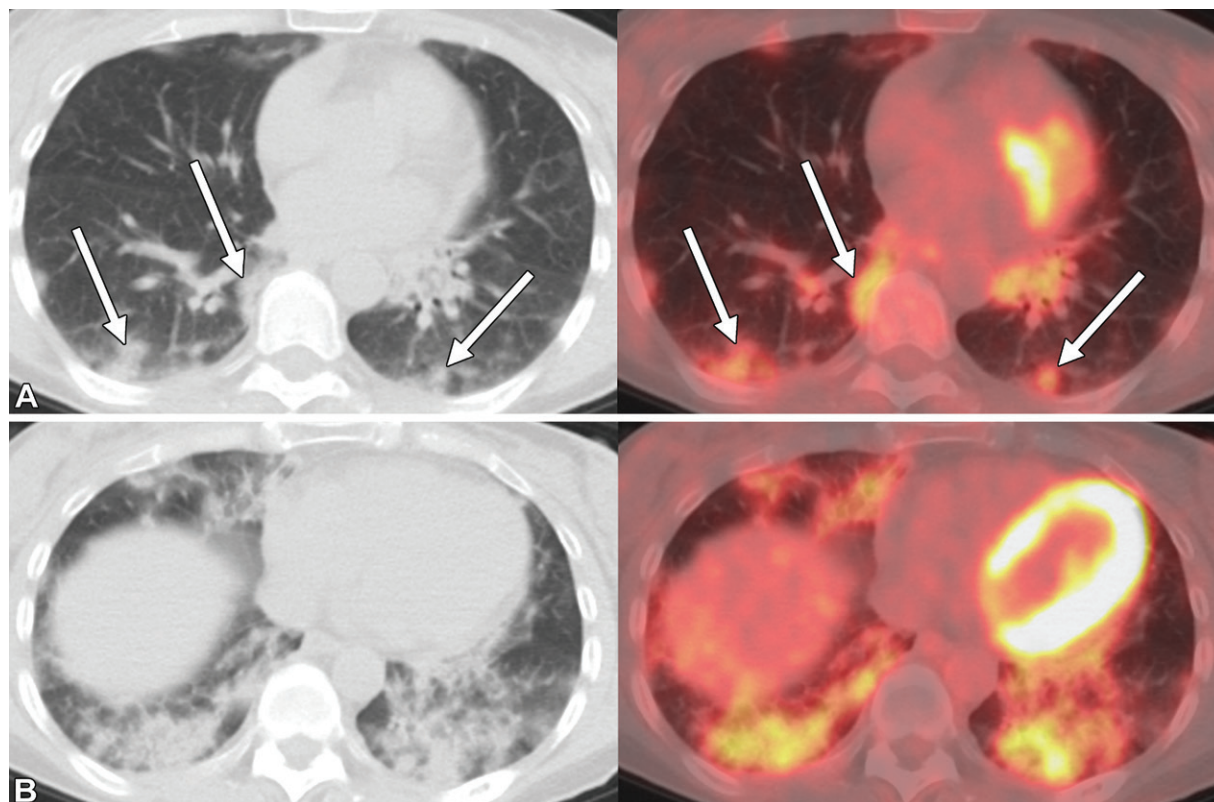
Checkpoint inhibitor immunotherapy–induced organizing pneumonia in a 58-year-old woman with metastatic melanoma, which was treated with nivolumab. Transaxial CT (left) and fused FDG PET/CT (right) images obtained at the level of the mid (A) and lower (B) thorax to monitor treatment response show new hypermetabolic peripheral and peribronchovascular consolidation and GGO, which are more confluent at the lung bases. This distribution, with findings of peripheral bandlike and small round consolidations in the mid lungs (arrows in A), is indicative of organizing pneumonia pattern pneumonitis. Nivolumab was discontinued, and follow-up surveillance FDG PET/CT (not shown) after 9 months of discontinuation showed improved consolidation and GGO, with uptake similar to that in the blood pool. After 2 years, the findings had essentially resolved.
